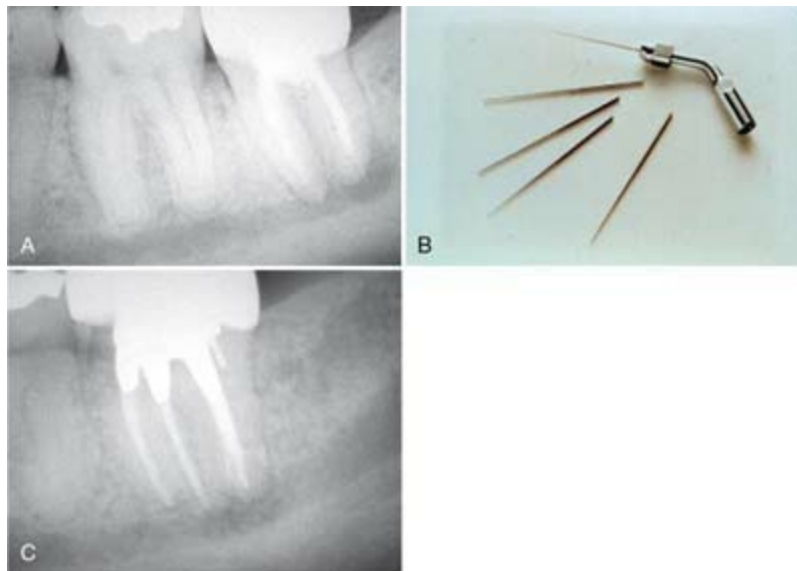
A, Preoperative radiograph of a hard paste root filling exhibiting a short fill, inadequate seal, and periapical radiolucency. Note the proximity of the inferior alveolar canal. B, Ultrasonic files like this were used to break up the hard paste in the apical third of the canal allowing removal. C, Seventeen-month postoperative follow-up. The patient is asymptomatic and has no paresthesia.
